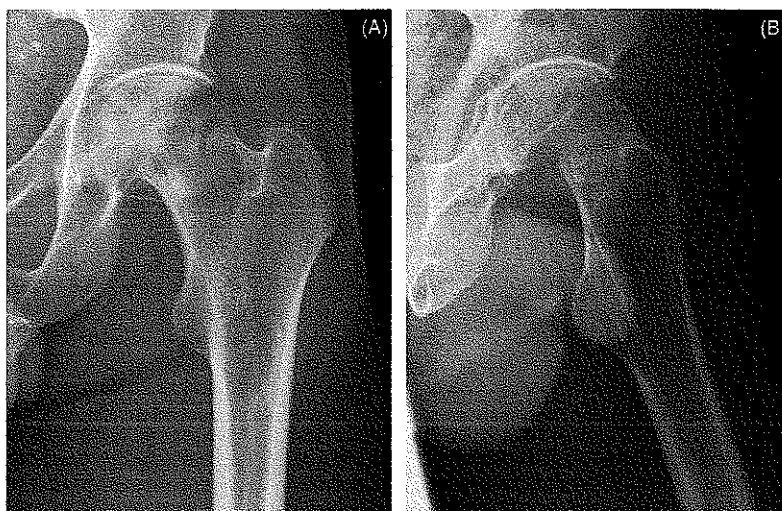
Intracapsular hip fracture, trauma X-ray. (A) AP view and (B) lateral view.
